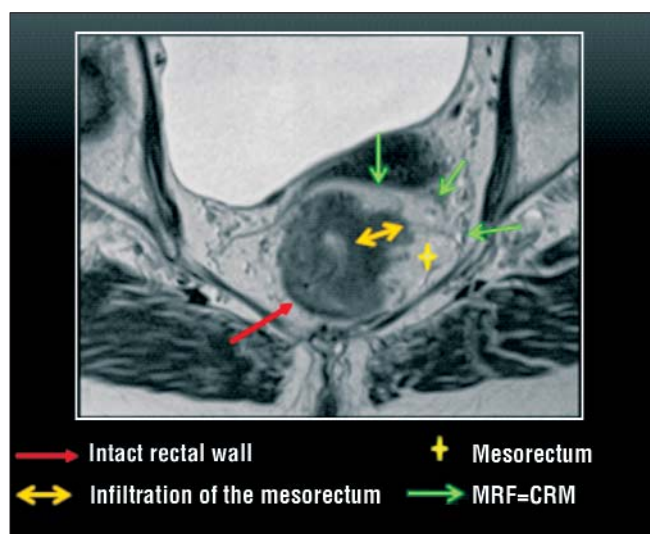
T3 stage T2 paraaxial MRI, presenting a solid tumour invading the mesorectal fat - a typical appearance of T3 tumours
